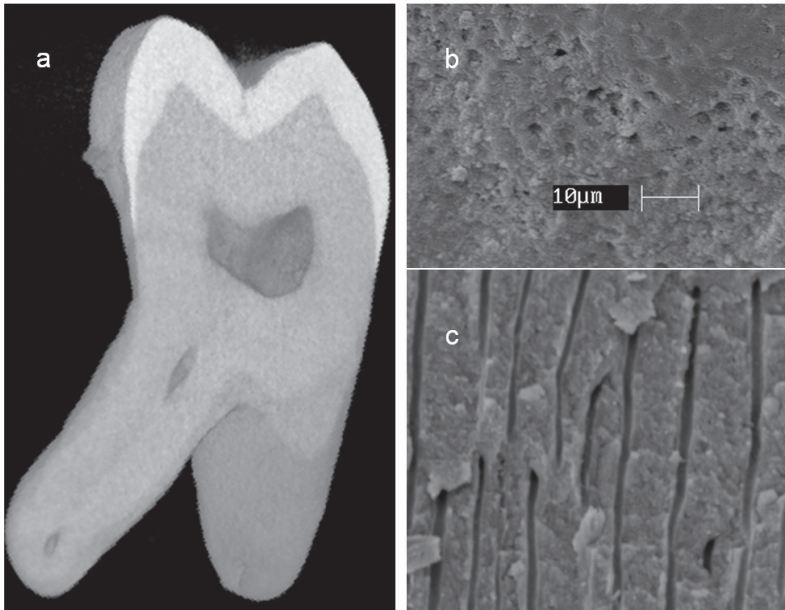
(a) 3-D reconstruction of a micro X-ray CT of a human third molar; (b) SEM image of a horizontal section from the dentine crown; (c) SEM image of a longitudinal section from the dentine crown (courtesy of Dr. D. Prisco, School of Dentistry, University of Naples Federico II, Naples, Italy.)
